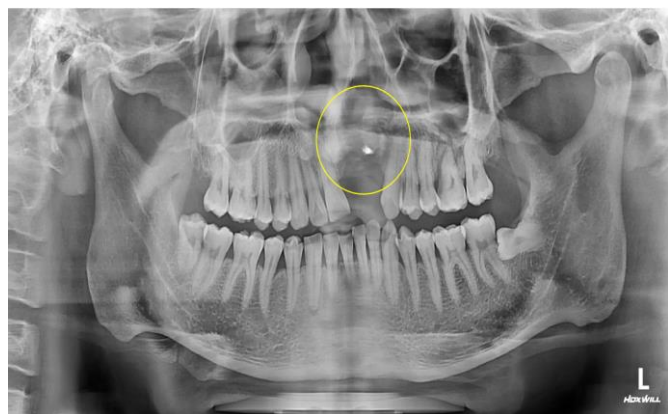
Panoramic radiograph of the patient's father (Yellow circle located in the cleft palate, there is no bone tissue between nasal and oral cavities. The opaque shadow may be a residual dental biomaterial from anamnesis patients father)
